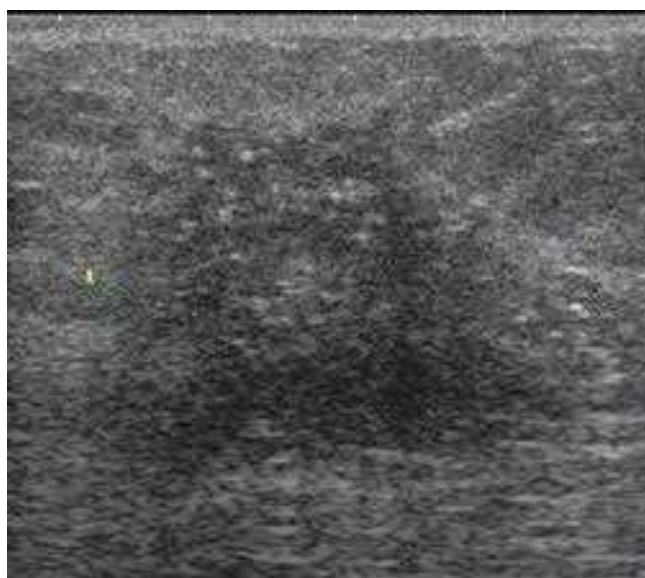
Ultrasonography images of benign breast tumors. A. Fibroadenoma. B. Intraductal papilloma. (Photos used with permission of Dr. Anne Turnbull, Consultant Radiologist/Director of Breast Screening, Royal Derby Hospital, Derby, UK.)
